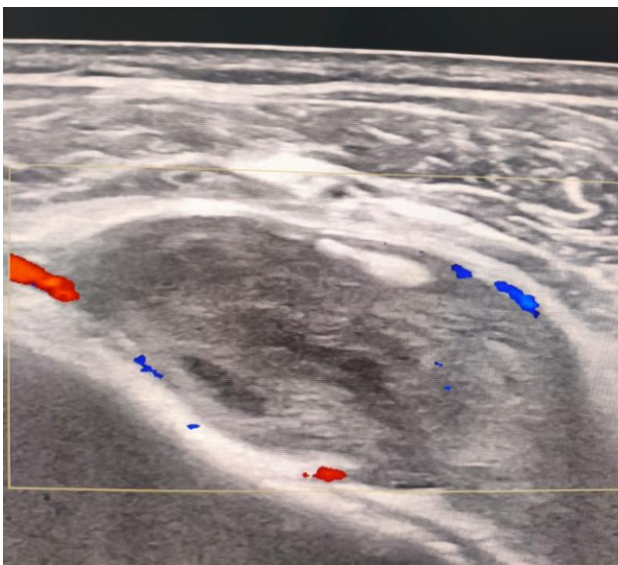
Doppler ultrasound of the right shoulder demonstrating a lobulated hypoechoic collection along the long-head biceps tendon sheath with peripheral vascularity, consistent with infective tenosynovitis.
